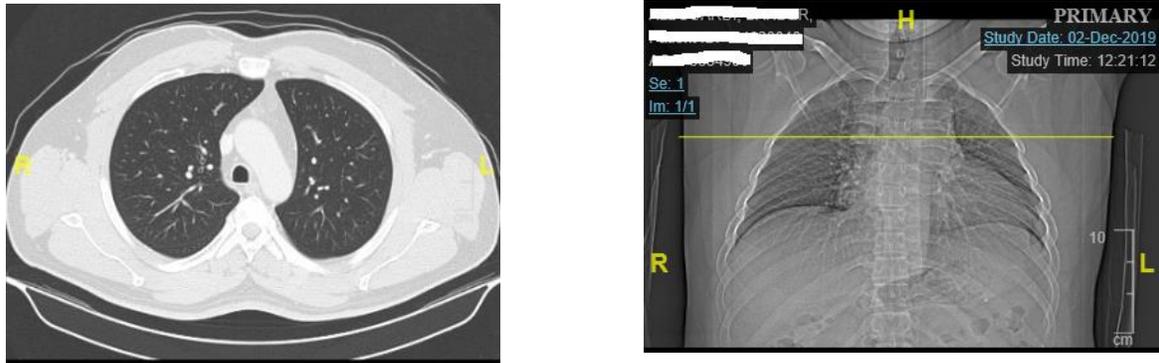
Chest CT scan before the bronchoscopy procedure which shows a lobulated soft tissue mass in the mid trachea causing narrowing of its lumen as described above Incomplete study with no definite other intrathoracic lesions.
